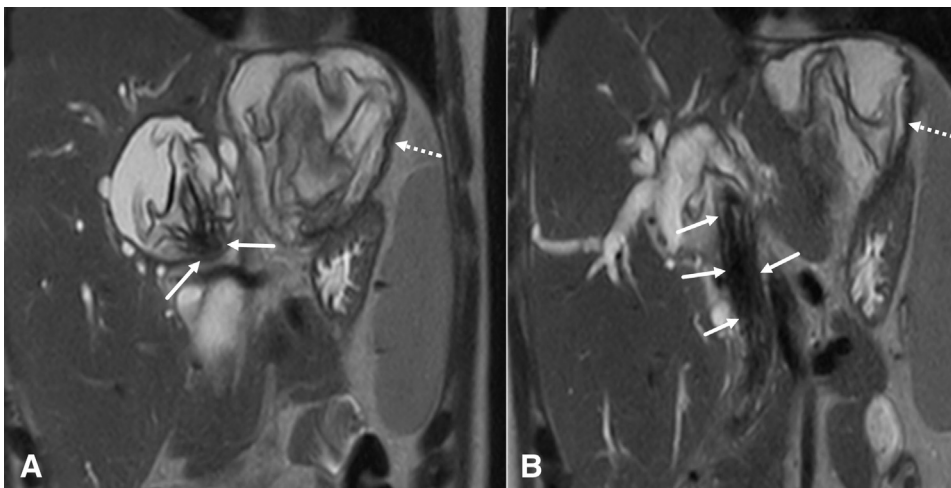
Consecutive coronal T2-weighted fast spin-echo magnetic resonance images (A, B) show cyst rupture into the common hepatic duct and hydatid cyst membranes in the common bile duct (white arrows). Another hydatid cyst also seen on segment II (white dashed arrows).
